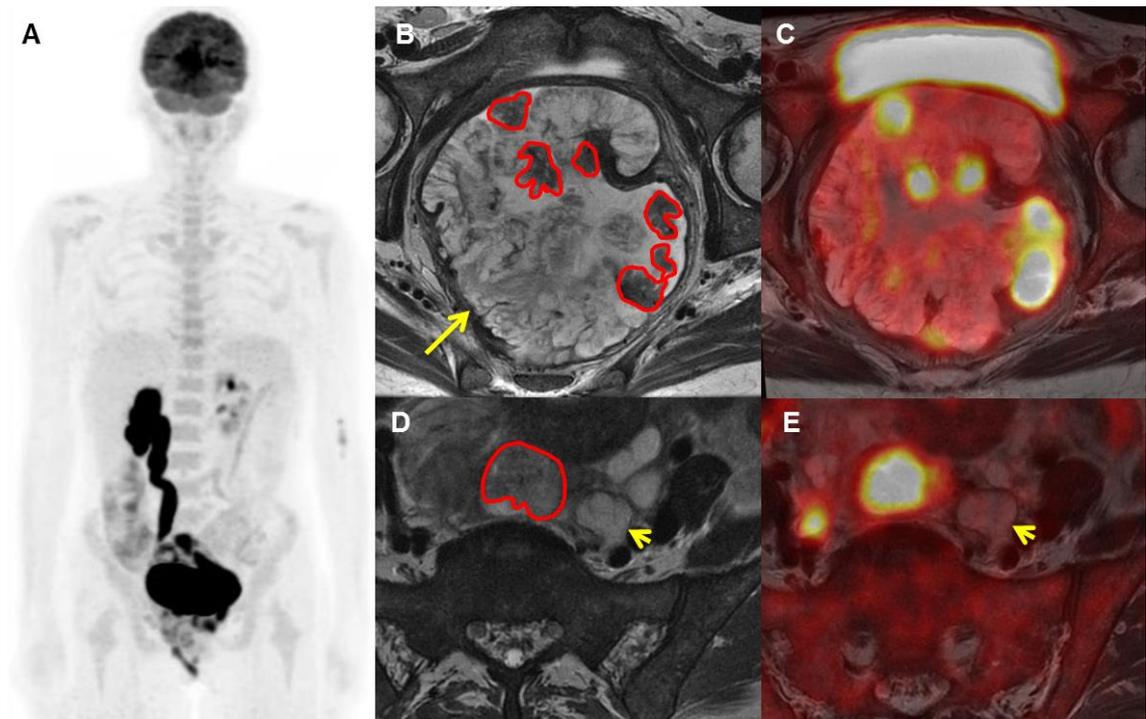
Difference between tumor metabolism between MC and NMC within primary rectal tumor and nodal metastasis. Female, 49 years old, presenting an extensive primary rectal tumor predominantly with MC (yellow arrow on B) with minimum FDG uptake (C) and a small part of NMC (curved red circles on B) with intense FDG uptake (C). Note that the metastatic retroperitoneal enlarged lymph node presents almost exclusive MC (short yellow arrow on D) without FDG uptake on fused images (E). Conversely, the MC in the upper part of the primary lesion (curved circle on D) present a high FDG uptake (E).
